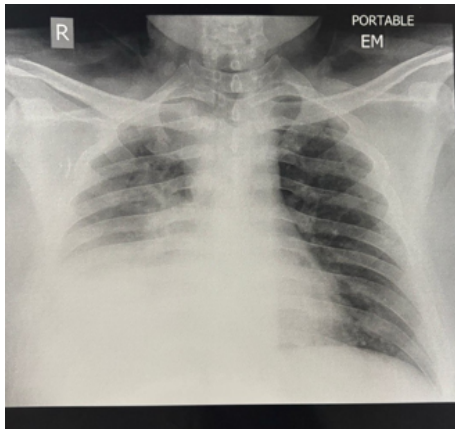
Chest radiography suggesting left lower lobe pathology correlated with computed tomography thorax
